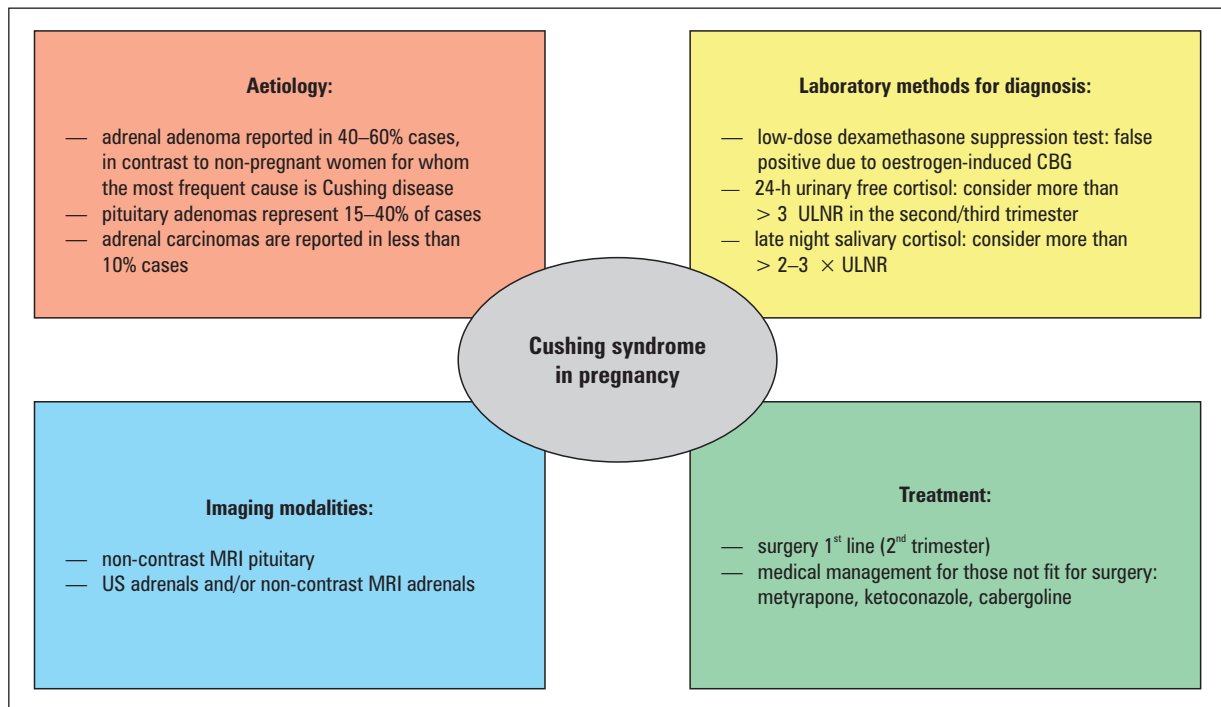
General characteristics of Cushing syndrome in pregnancy [4, 11]. ULNR — upper limit of normal range; MRI — magnetic resonance imaging; US — ultrasound scan; CBG — corticosteroid-binding globulin
